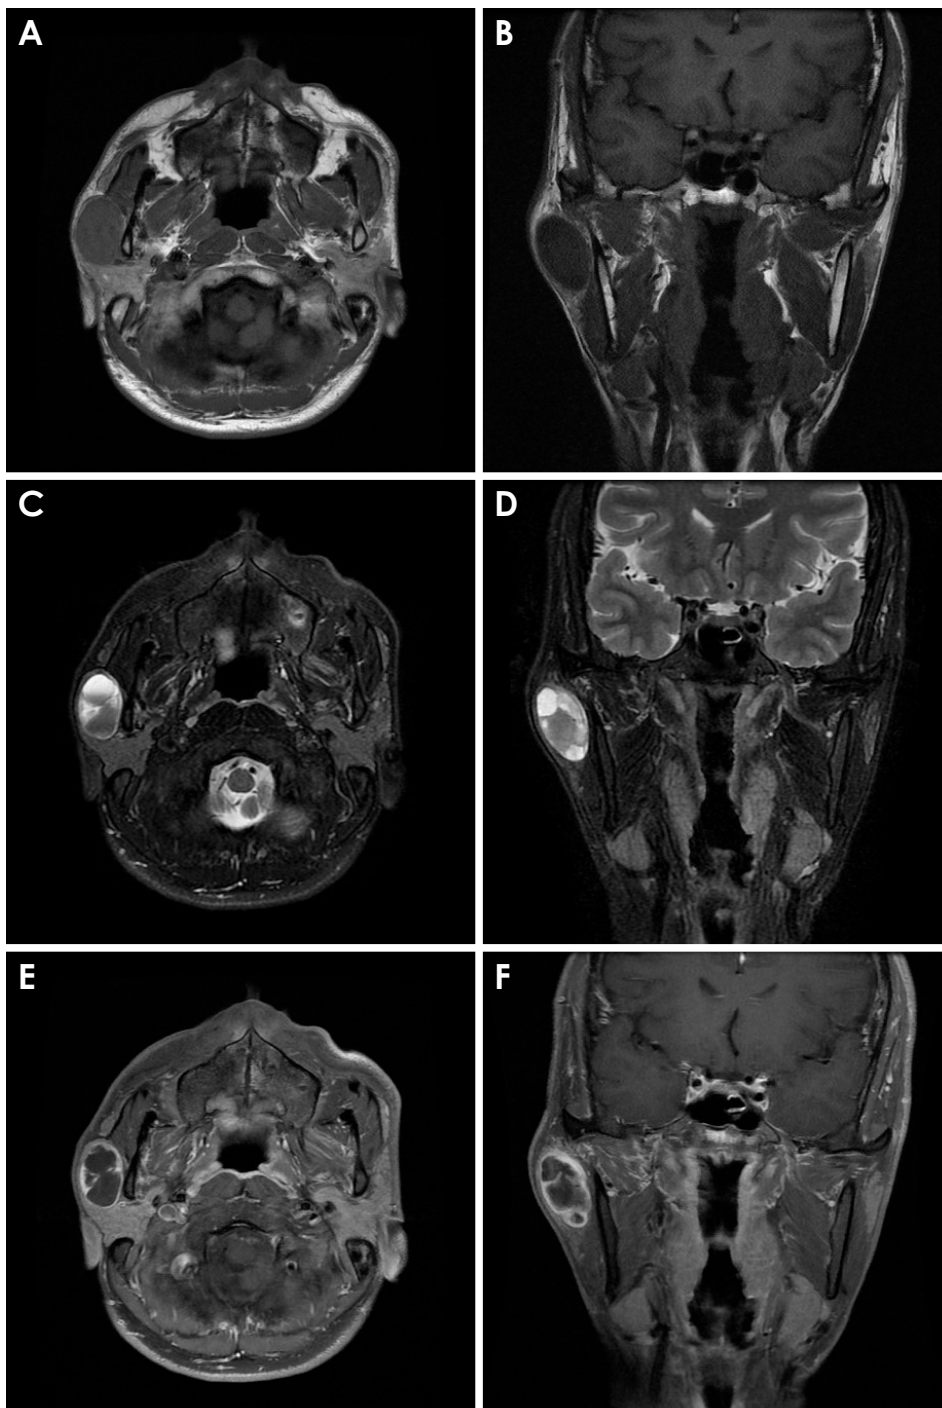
Axial (A) and coronal (B) T1-weighted magnetic resonance (MR) images show a well-defined homogeneous hypointense mass of the right parotid gland area. Axial (C) and coronal (D) T2-weighted MR images show the ovoid mass with multilocular hyperintensity and a partially hypointense signal. Axial (E) and coronal (F) fat-suppressed enhanced T1-weighted MR images show the lesion with a high signal along the lobulated margin and an internal homogeneous low signal.
